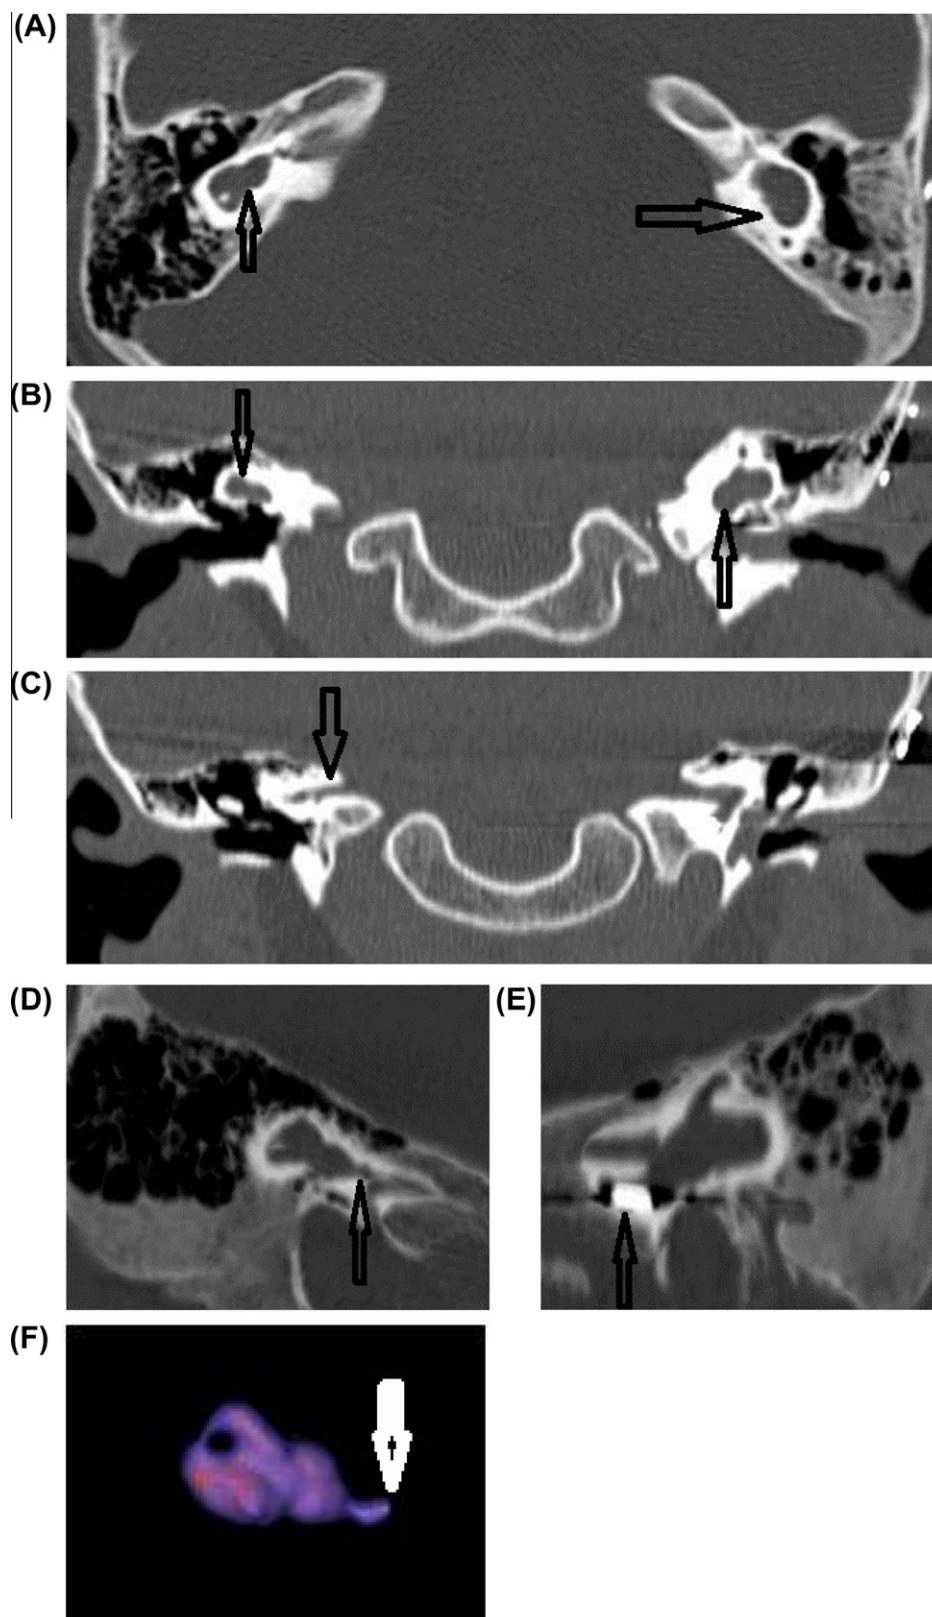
A case of right sided A1,4,5 D2,3 N1 and left sided D1–4 N0 anomalies. (A and B) Axial and coronal CT images demonstrating dysplastic formation of the remaining portions of the labyrinth (arrows). (C) Coronal CT imaging showing stenotic (aplastic) right IAC (arrow) compared to the left side. (D) and (E) are Min. IP images of the labyrinth and F VR image of the right labyrinth. The absent cochlea (A1 anomaly) is shown by arrows in (D) and (F) with dysplastic rudimentary bud. This child had bilateral anomalies and left sided cochlear implant (arrow in E) was inserted considering that the contra-lateral (right) VIII cranial nerve was absent.
